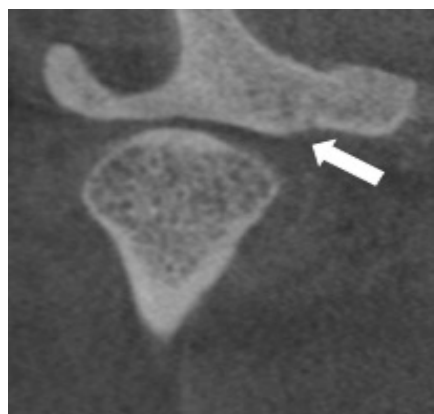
CBCT REVEALING GLENOID FOSSA FLATTENING
